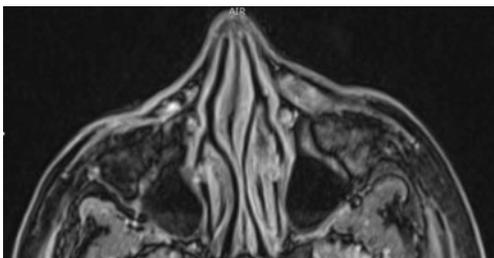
T1 axial MRI showing left-sided diffuse lesion in the nasolabial fold
